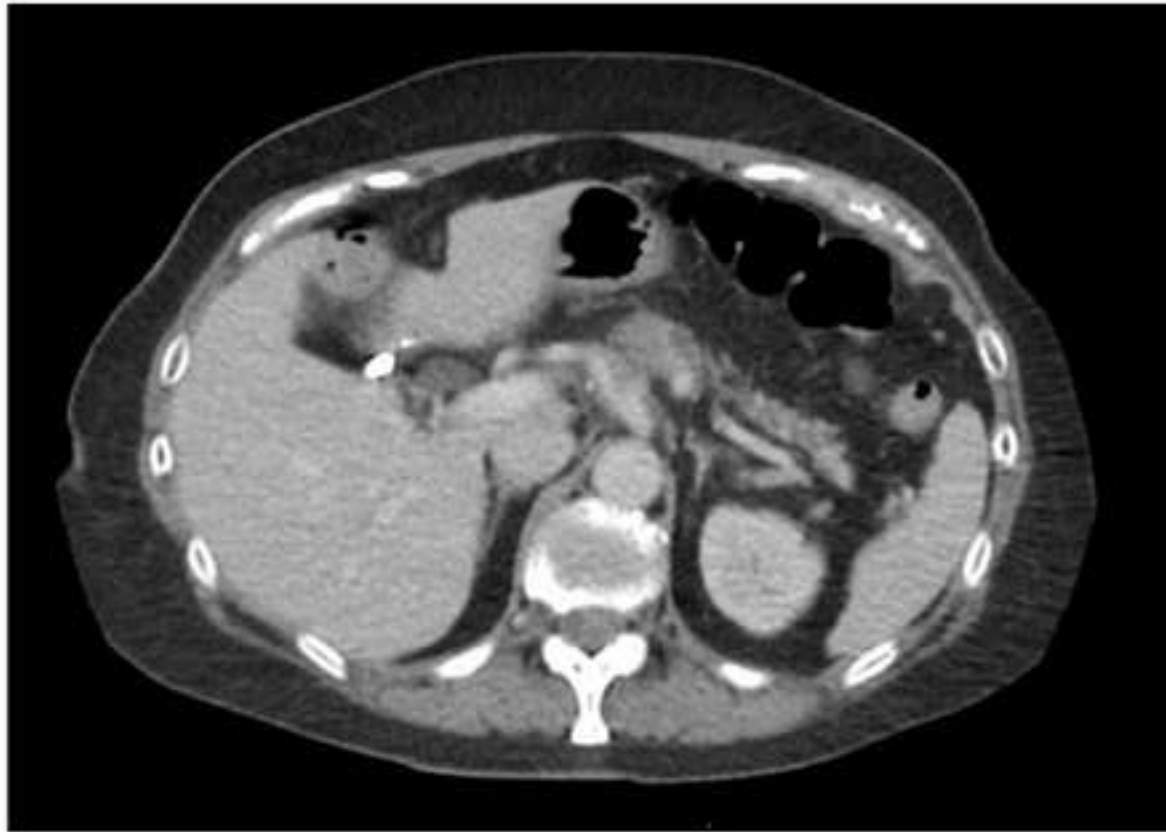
Post-treatment CT imaging demonstrating locally advanced body of pancreas mass involving celiac axis and splenic vein with persistent soft tissue infiltration surrounding celiac axis
